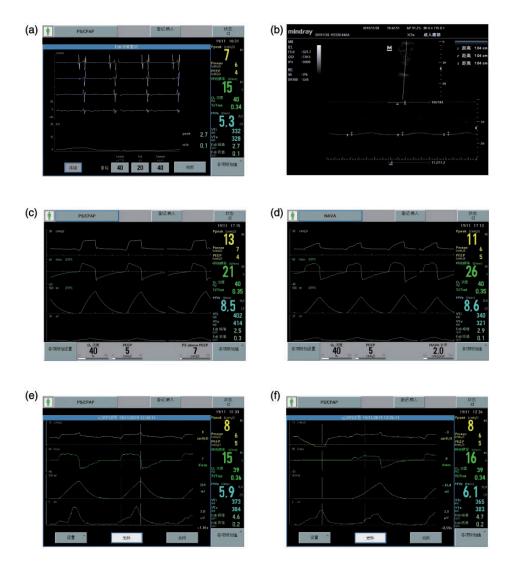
Study methods. (a) Confirmation of the catheter position. (b) Measurement of diaphragmatic movement using a 3.5-MHz ultrasonography probe in two-dimensional mode. (c, d) Representative case involving PSV and NAVA. (e) Measurement of NVE, calculated as tidal volume / peak electrical activity of the diaphragm. (f) Measurement of NME, calculated as (positive end-expiratory pressure – minimal airway pressure) / peak electrical activity of the diaphragm.
